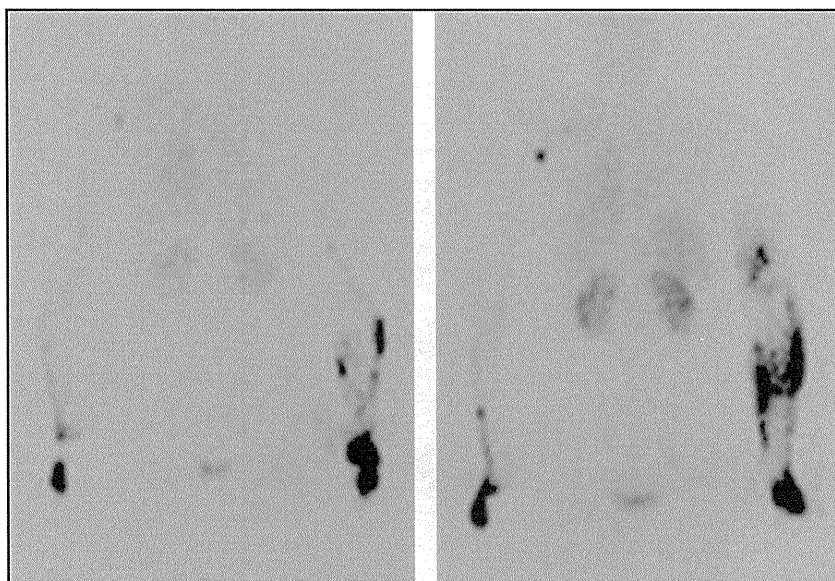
Lymphoscintigraphy images of a case of Type III-Subtype 0 lymphedema in the left arm. The left and right panels show images taken 30 and 120 min, respectively, after injection of a contrast medium. Lymph nodes around the clavicle were not observed even on the image taken at the later time point. DBF was found in the upper arm and forearm of the affected side on the image taken 120 min after injection.
